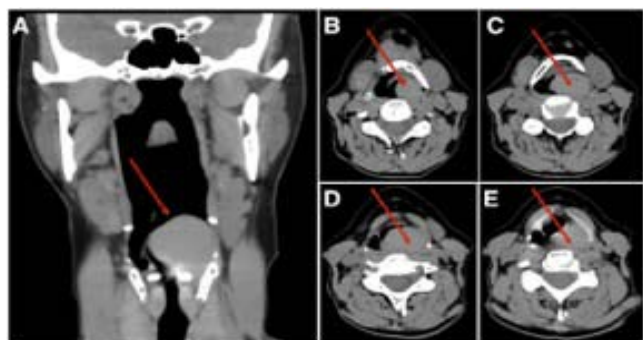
CT neck showing left supraglottic mass on coronal (A) and axial (B-E) sections.
